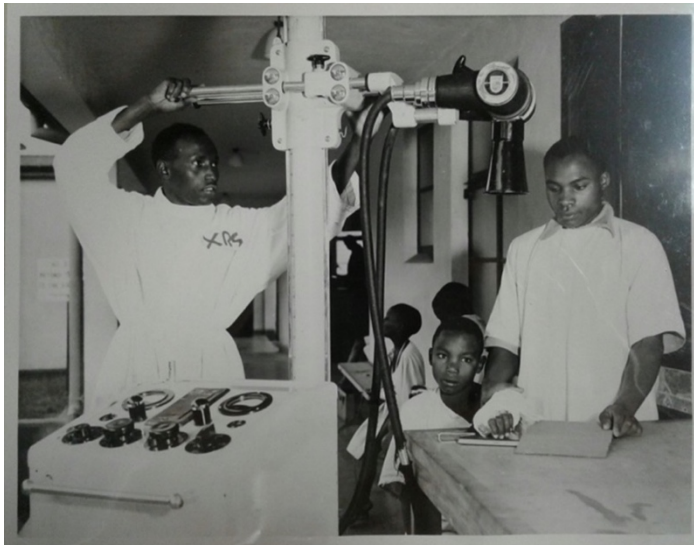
“A Kikuyu, Peter Mugubu, is one of the 4 trainees who have just completed their radiographers” course. He is seen here (L) handling modern X-ray equipment at the King George VI Hospital, Nairobi, where he spent some weeks for final study. 1960, INF 10/156/123 (Part 7), The National Archives, London.
